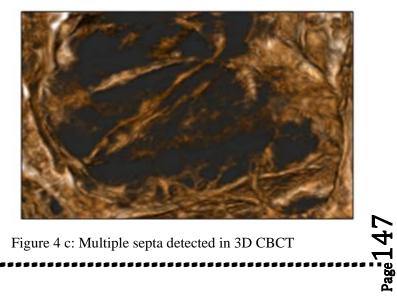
c: Multiple septa detected in 3D CBCT
